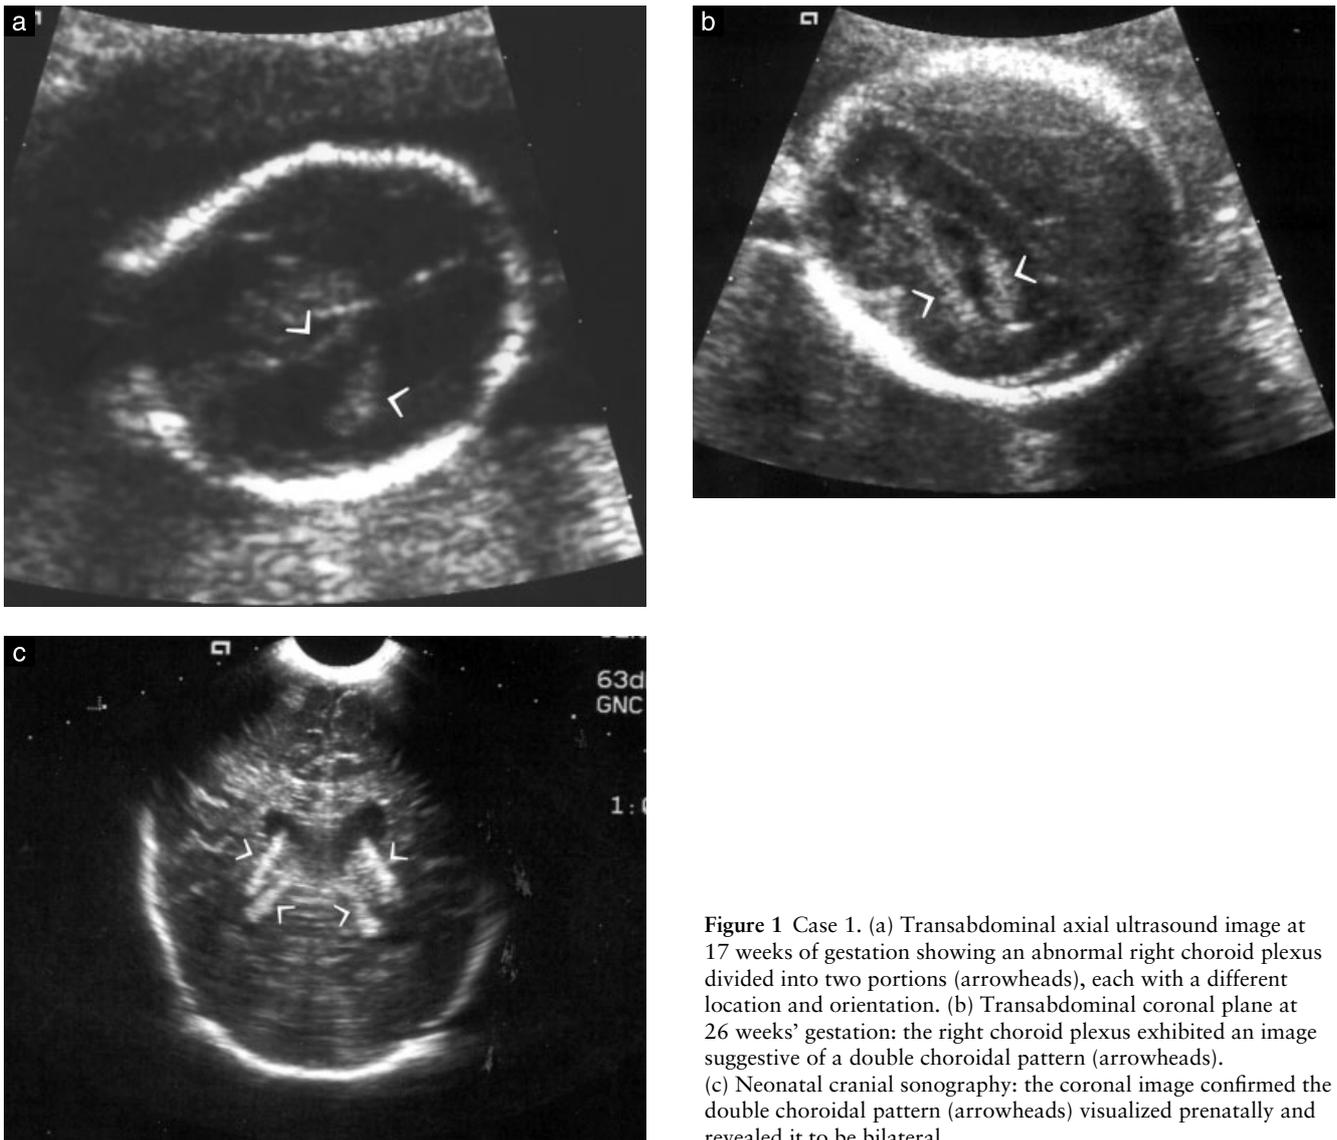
Case 1. (a) Transabdominal axial ultrasound image at 17 weeks of gestation showing an abnormal right choroid plexus divided into two portions (arrowheads), each with a different location and orientation. (b) Transabdominal coronal plane at 26 weeks' gestation: the right choroid plexus exhibited an image suggestive of a double choroidal pattern (arrowheads). (c) Neonatal cranial sonography: the coronal image confirmed the double choroidal pattern (arrowheads) visualized prenatally and revealed it to be bilateral.
